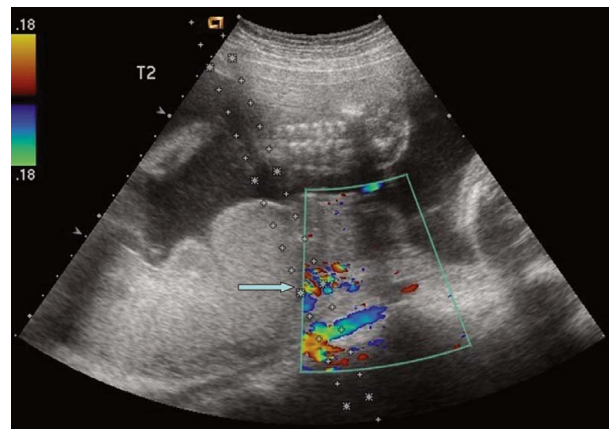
Ultrasonographic image shows the *in utero* appearance of the placenta of the monochorionic twin pair before embolization. The interfetal vascular anastomoses within the placenta are easily identifiable (arrow).
